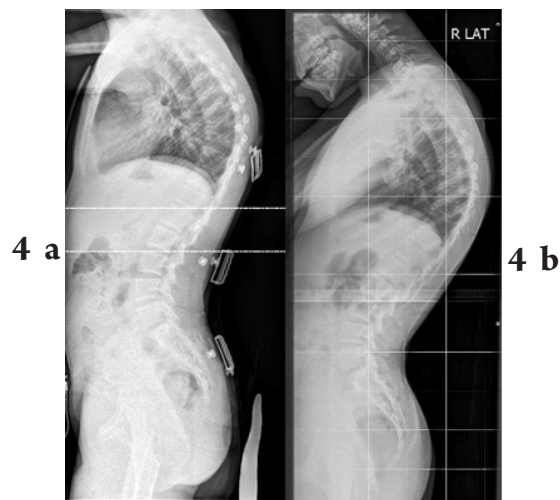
a On first presentation; 4 b Radiograph in follow up appointment
